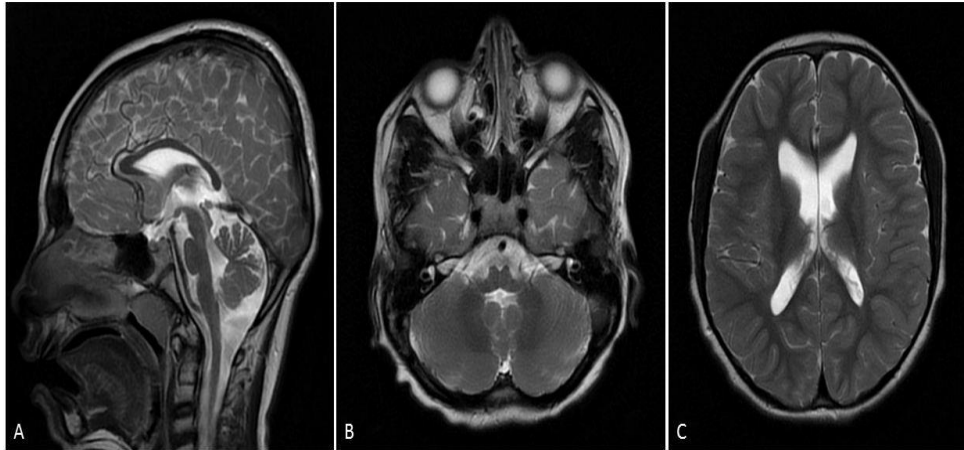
9-year-old male. A) Hypoplasia of brain stem compartments and corpus callosum on the sagittal T2-weighted image. B) Normal cerebellum on the axial T2-weighted image. C) Slight dilatation of the lateral ventricles on the axial T2-weighted image.
